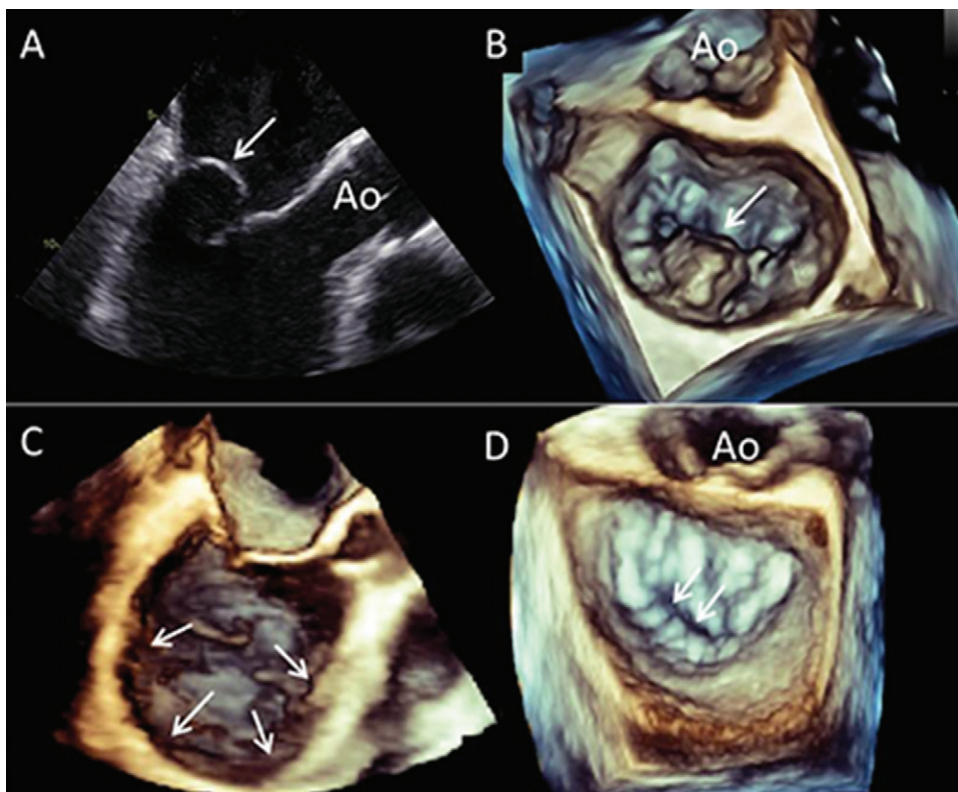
Mitral regurgitation mechanism. *A*, Two-dimensional transesophageal echocardiography; example of primary mitral regurgitation caused by prolapse of the posterior mitral leaflet (arrow). *B*, On three-dimensional transesophageal echocardiogram, the en face view of the mitral valve permits exact location and extent of the prolapsing scallop (central scallop P2, arrow). *C*, Example of secondary mitral regurgitation caused by dilatation of the left ventricle (arrows) and subsequent tethering of the leaflets. *D*, The en face view of the mitral valve on three-dimensional transesophageal echocardiogram shows lack of coaptation between the anterior and posterior leaflets and the central level (arrows). Ao = aortic valve.
